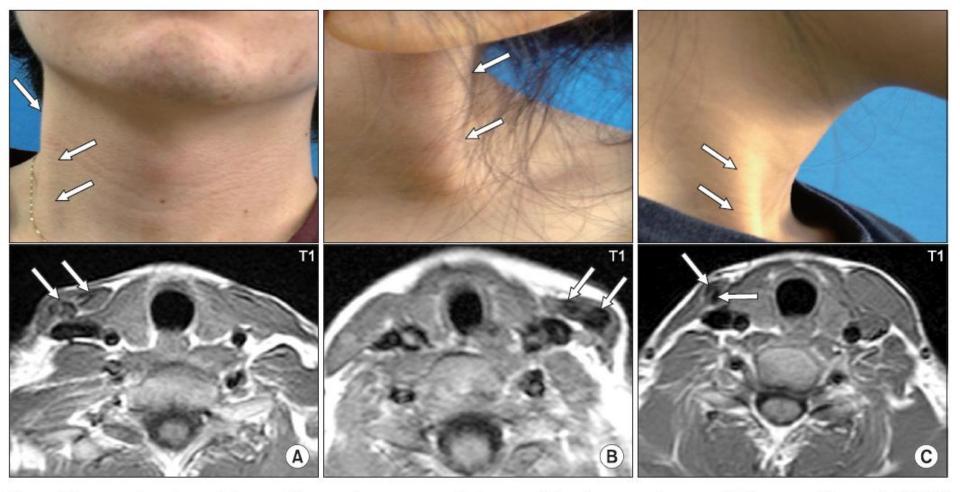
Pictures showing subjects with atrophy or same thickness of the shortened sternocleidomastoid muscle (SCM) with low signal intensities on the T1-weighted axial images of the SCM. (A) Twenty-two year old man with right congenital muscular torticollis (CMT) showing a cord-like right SCM (arrows). Neck MRI showed low signal intensities (arrows) and did not show significant difference of thickness between the right and left SCM. (B) Five year old girl with left CMT showing a cord-like left SCM (arrows) and low signal intensity (arrows) on left SCM. (C) Twenty year old woman with right CMT showing atrophied cord-like right SCM (arrows) with low signal intensity (arrows) on right SCM.
